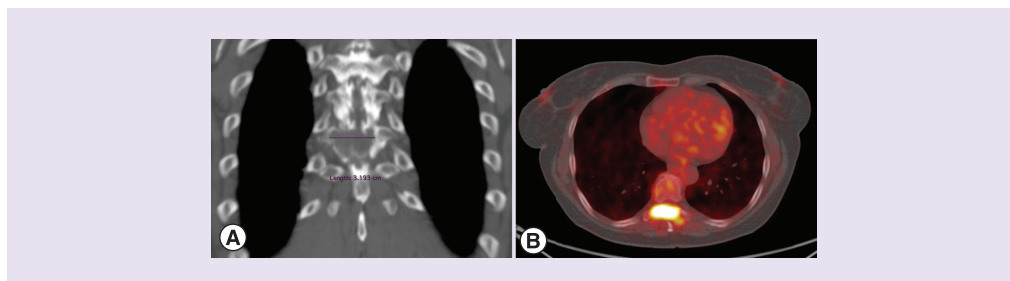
Metastasis at vertebra T8 prior to the treatment with lenvatinib. (A) CT scan of dorsal spine in coronal view. (B) A concomitant PET scan (axial view) showed intense ^{18}F FDG uptake in T8.
